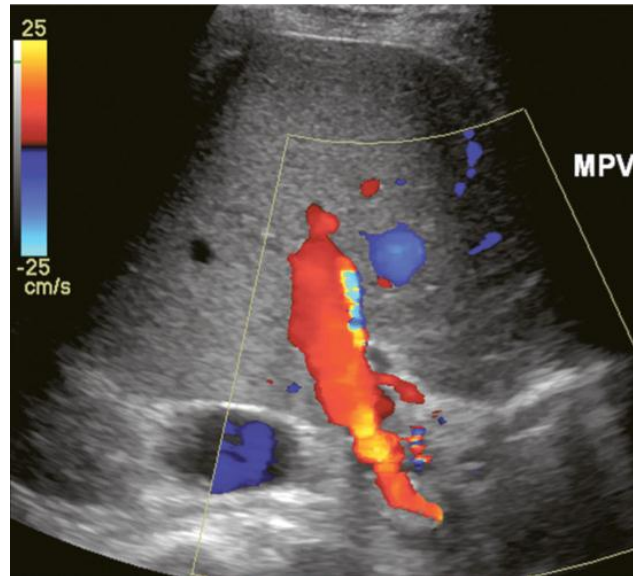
Oblique colour Doppler image of the porta hepatis. The hepatic artery (HA) accompanies the portal vein (PV) and bile ducts. With the colour scale appropriately set for the slow flow within the portal vein, hepatic arterial flow projects as colour aliasing. (Myron A Pozniak et al 2014)
